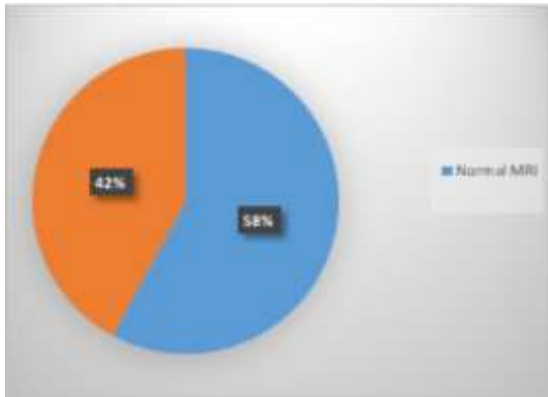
Frequency of abnormal MRI vs Normal MRI in seizures
